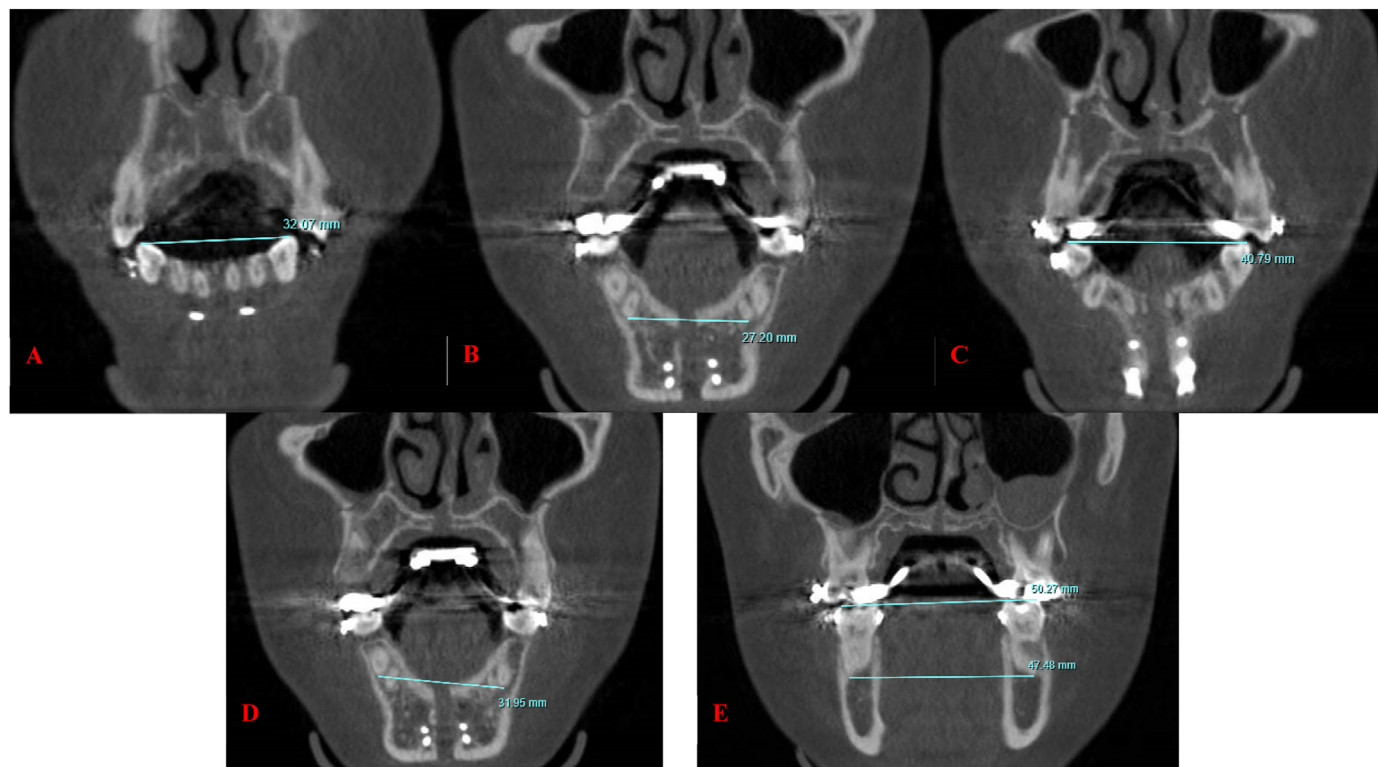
Dental measurements regarding bone-borne vs tooth-borne MMD using coronal CBCT slices at T1, T2 and T3. A: MANICTD; B: MANICAD; C: MANIFPTD; D: MANIFPAD; E: MANIFMTD, MANIFMAD.
